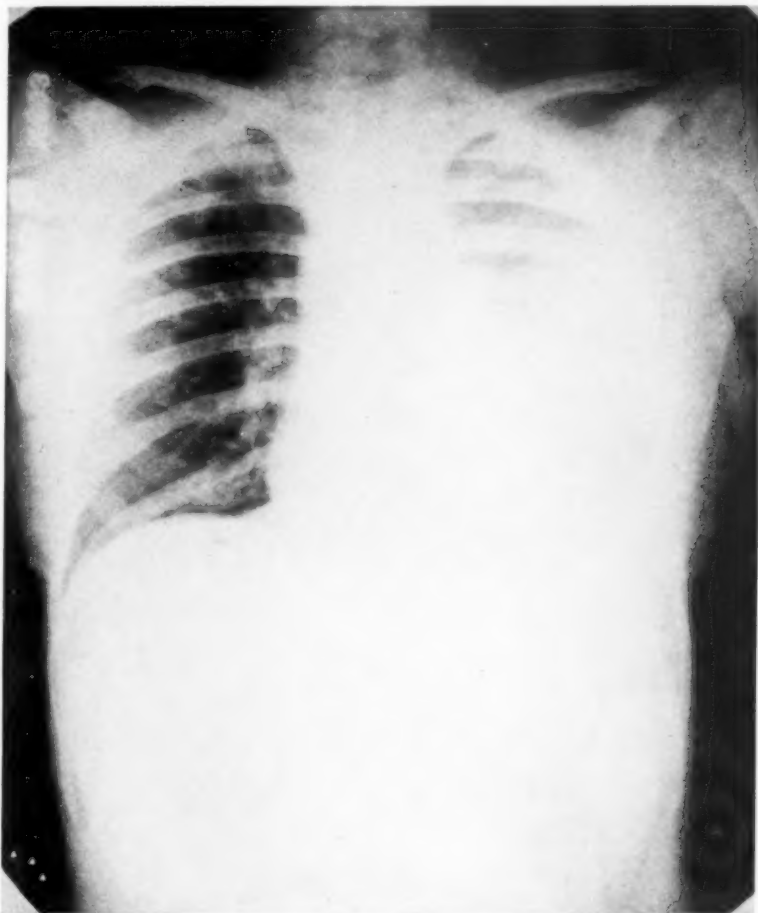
Roentgenogram during the active stage of the left pneumonitis and pleural effusion and before the development of clinical evidence of pericardial effusion (December 2, 1936).
